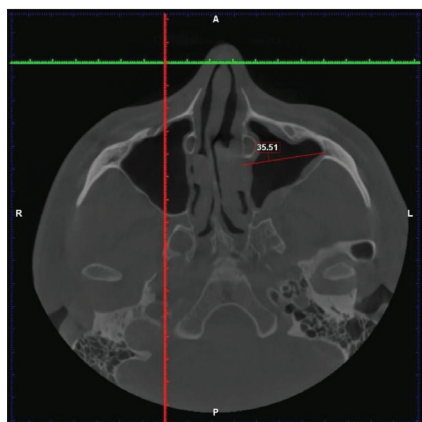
Mediolateral dimension of the maxillary sinus on axial projection of cone-beam computed tomography
